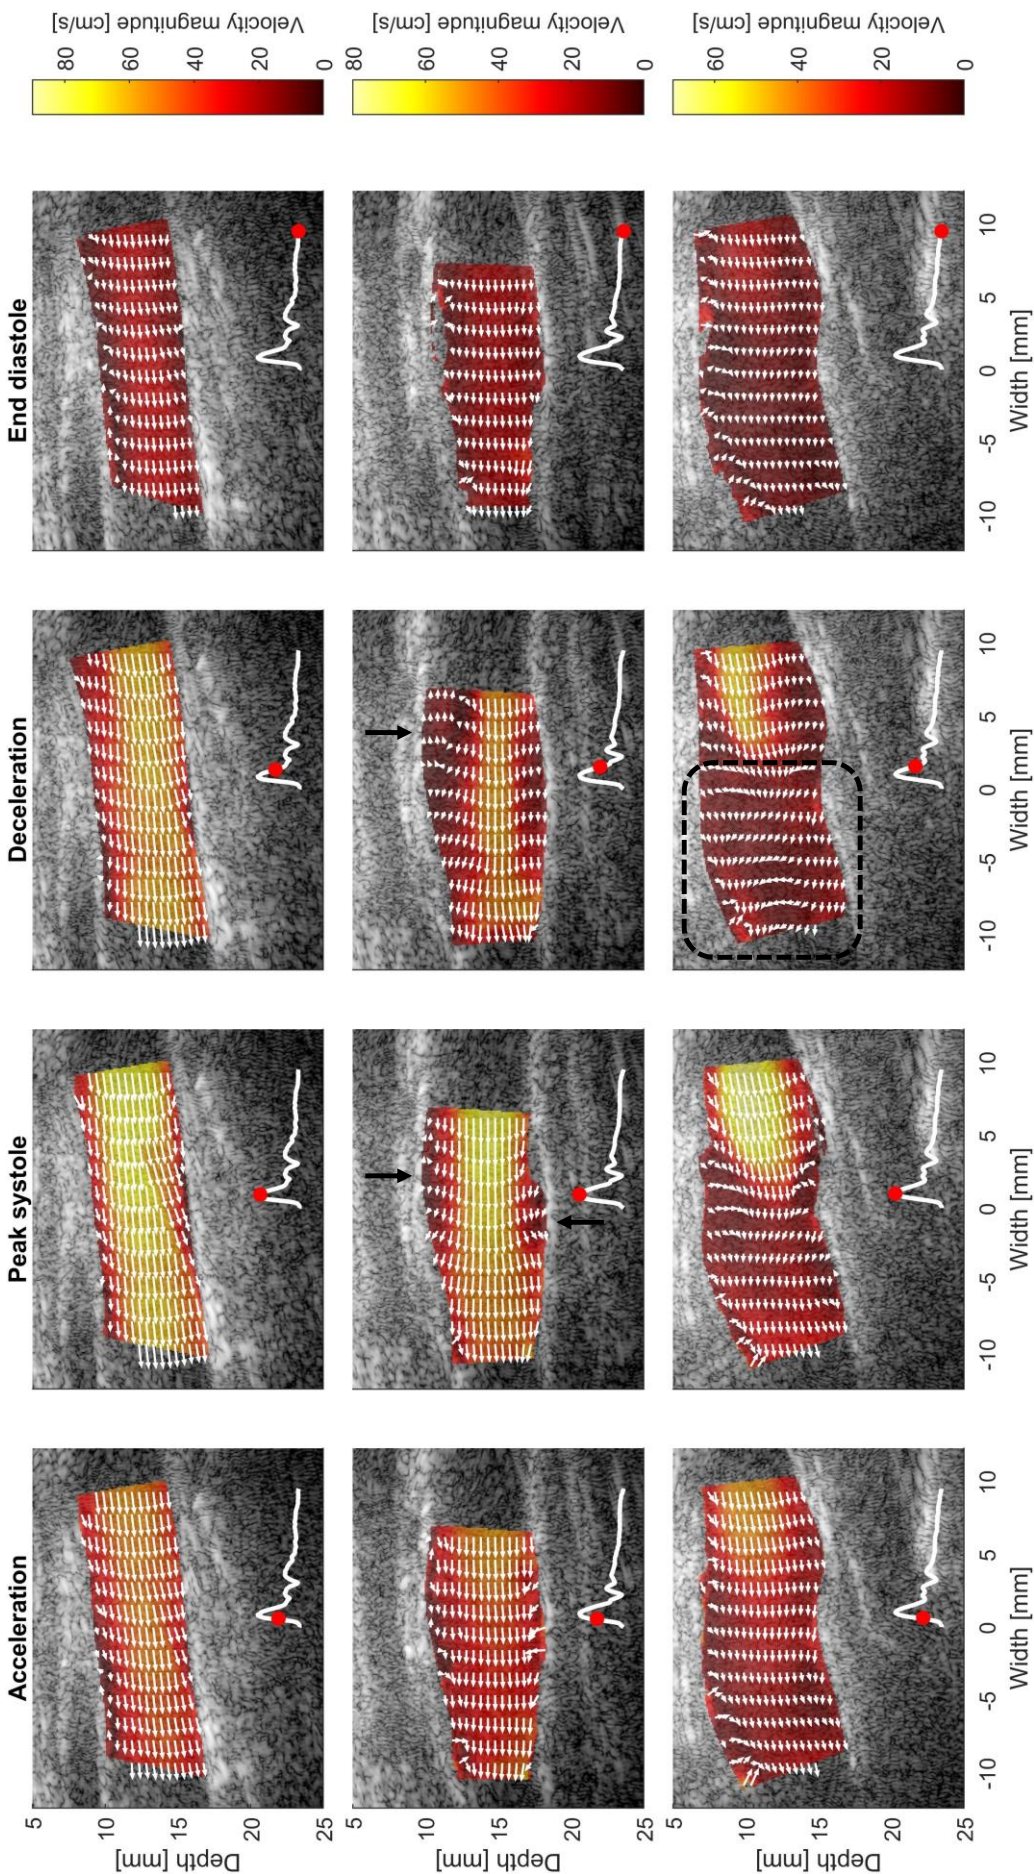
Ultrasound-based velocity vector imaging in the carotid bifurcation of (upper row) a 30 y/o female, (mid row) a 24 y/o female, and (bottom row) a 67 y/o male. Velocities vectors (white) are represented on a mask of velocity magnitudes at accelerating systole, peak systole, decelerating systole and end diastole. These timepoints are annotated in the temporal profile (right-bottom corner of each image). Recirculating flow patterns were annotated with black arrows and complex blood flow patterns, caused by out-of-plane blood flow, was annotated with a black dotted rectangle.
